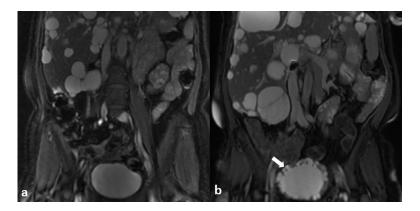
Coronal SSFP MRI of the bladder (a) prior to botox injection and (b) at presentation 3 months post the second bladder botox injection. Note the increased bladder wall thickness (solid white arrow) with multiple cyst-like diverticuli and thick trabeculations. Also note multiple cysts enlarging the liver (open white arrow) related to her ADPKD.
